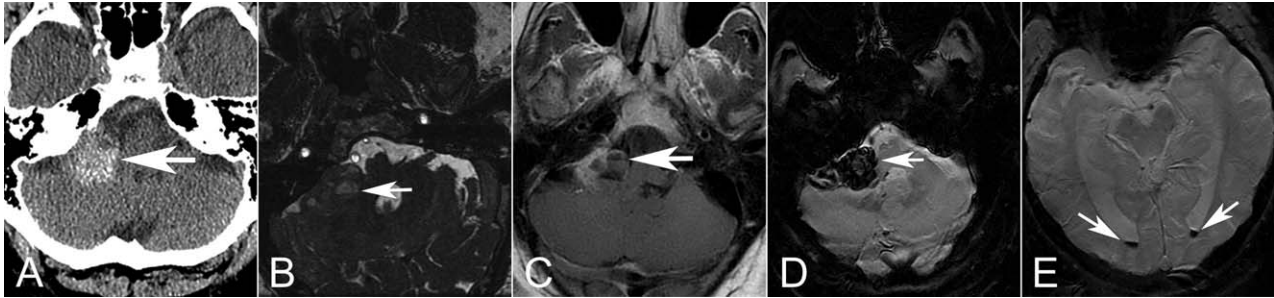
A 68-year-old man, with a history of hypertension and on anticoagulation, presented with acute headache, vertigo, facial paresis, and diplopia. (A) Axial computed tomography without contrast demonstrates increased attenuation within the vestibular schwannoma consistent with intratumoral hemorrhage (arrow). (B) Axial FIESTA image demonstrates hematocrit level (arrow) within cystic portion of the large vestibular schwannoma. (C) Axial T1 image with contrast reveals a nonenhancing cystic portion of tumor with fluid level (arrow). (D) Axial SWI demonstrates marked hypointense signal (arrow) within the tumor consistent with hemorrhage. (E) Axial SWI image at level of occipital horns of the lateral ventricles demonstrates dependent layered hemorrhage (arrows). SWI = susceptibility-weighted image.
